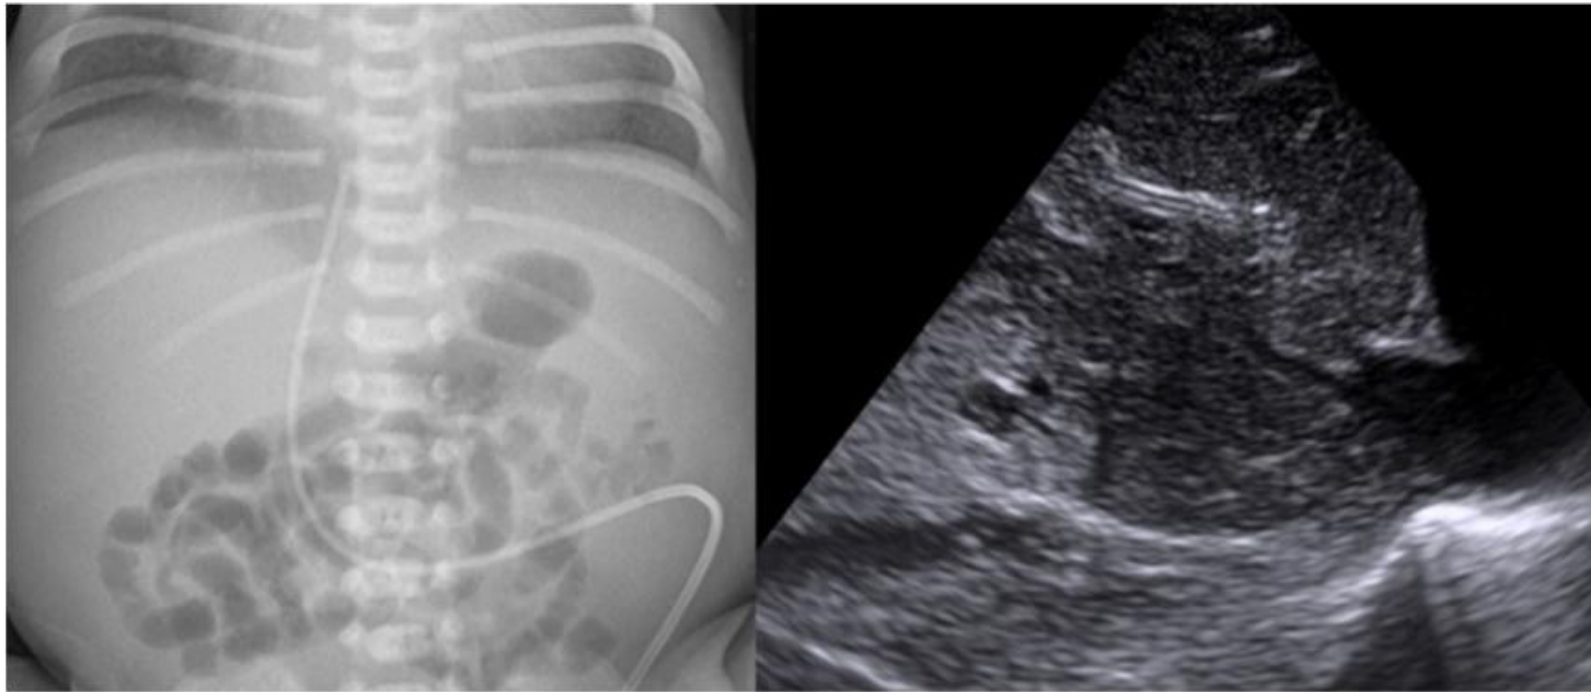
An umbilical venous catheter (UVC) outside the cardiac silhouette, below the level of the diaphragm and pointing towards the base of the right atrium on X-ray (and therefore felt to be in a safe position) which is shown on ultrasound to be penetrating the liver parenchyma.
